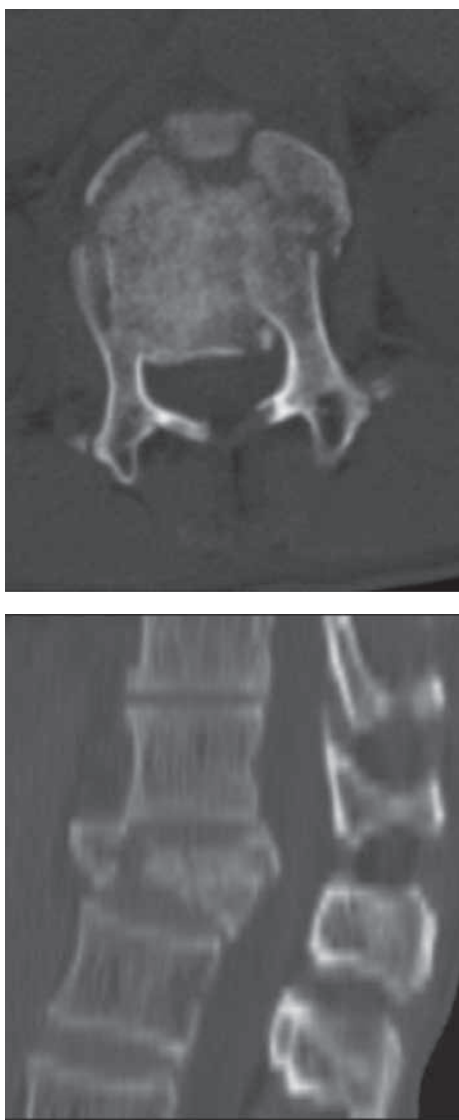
Preoperative CT-scan (plain and sagittal reconstruction image) of the patient showing the burst fracture with spinal canal encroachment.
